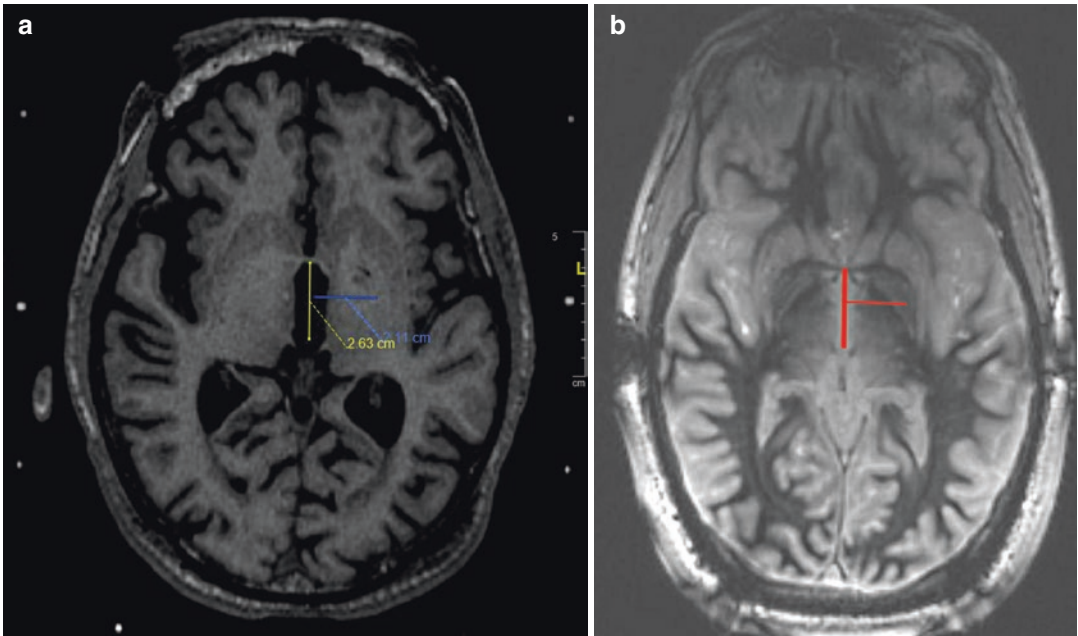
T1-weighted axial MRI demonstrating initial target in GPI at the level of the intercommissural plane 2–3 mm anterior to the midcommissural point and 21 mm lateral (a) better seen on axial proton density MR images that better defines GPI anatomy (b)
